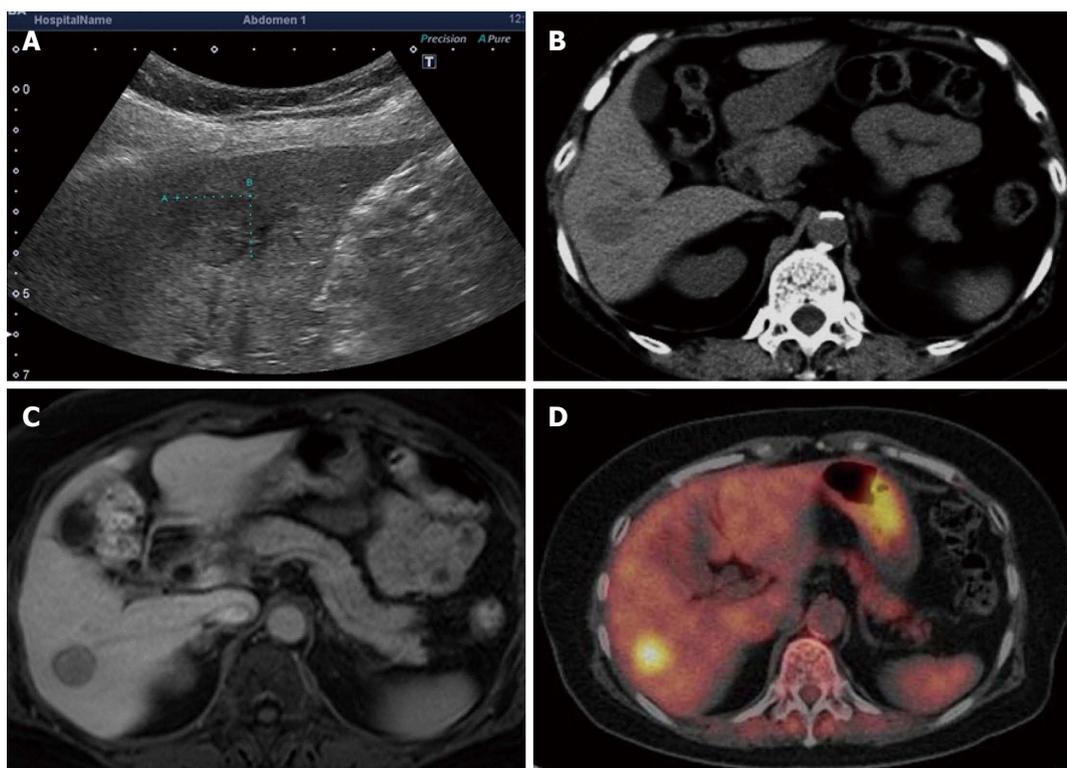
A mass approximately 15 mm in diameter was noted in the hepatic S6. A: Ultrasonography; B: Computed tomography scan; C: Magnetic resonance imaging; D: Positron emission tomography.
